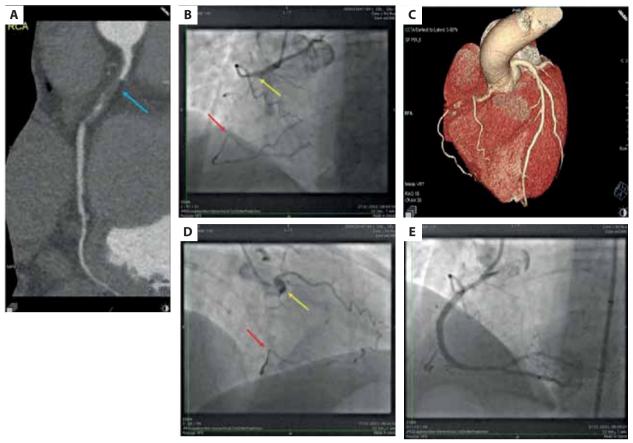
A. Multislice computed tomography (MSCT) — a 10 mm occlusion (blue arrow) in the proximal segment of the dominant right coronary artery (RCA). B. Right coronary artery (RAO 30° projection) — proximal occlusion (yellow arrow), blunt stump visible. From the ipsilateral collateral circulation, the middle and distal sections fill. End of occlusion (red arrow). The length of the occlusion assessed angiographically — approx. 40–45 mm. C. MSCT (RAO 18) — a 10 mm occlusion in the proximal segment of the dominant right coronary artery (RCA). D. Right coronary artery (LAO 30° projection) — proximal occlusion (yellow arrow), blunt stump visible. From the ipsilateral collateral circulation, the middle and distal sections fill. End of occlusion (red arrow). Angiographically assessed occlusion length — approx. 40–45 mm. E. Right coronary artery (RAO 30° projection), image after stent implantation
